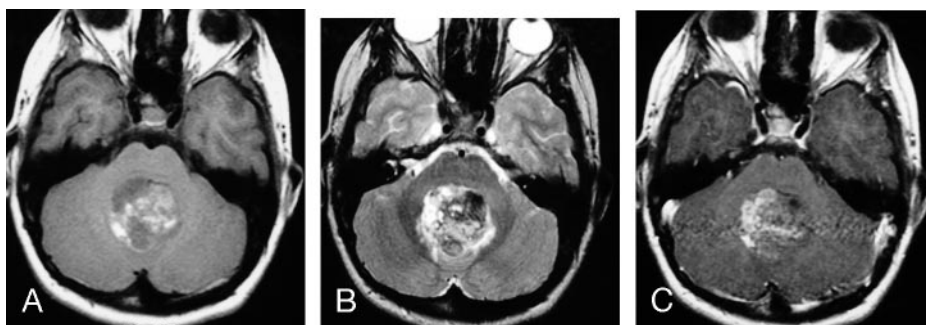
MR images of a 10-year-old boy with AT/RT in the vermis, extending into the fourth ventricle.
